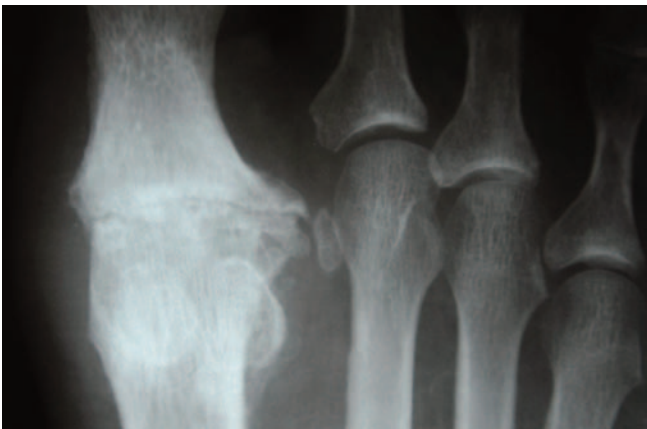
Case Study 1. Postoperative AP radiograph.
